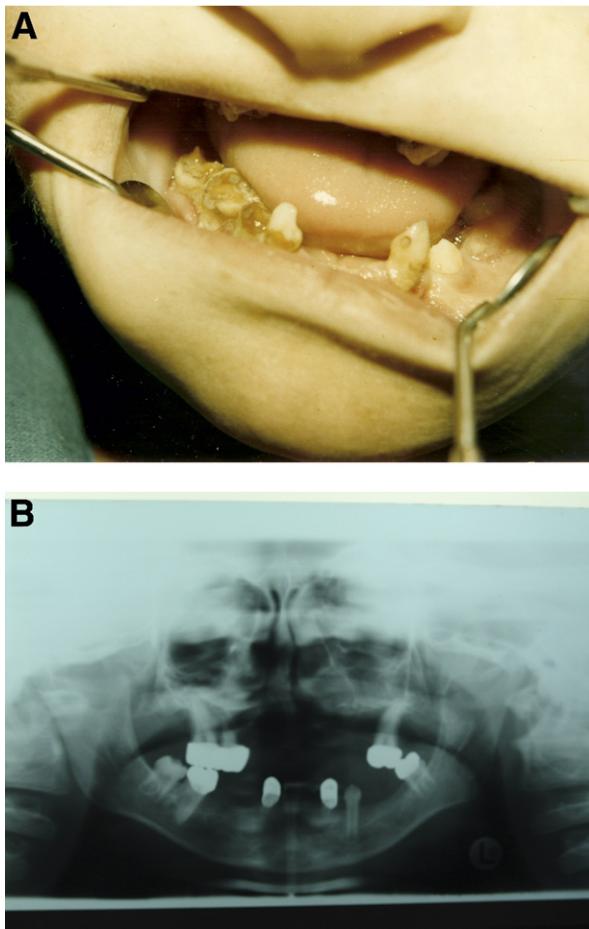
A, Dental abnormalities, anodontia, and enamel hypoplasia are noted. B, Panoramic roentgen film showing anodontia.
